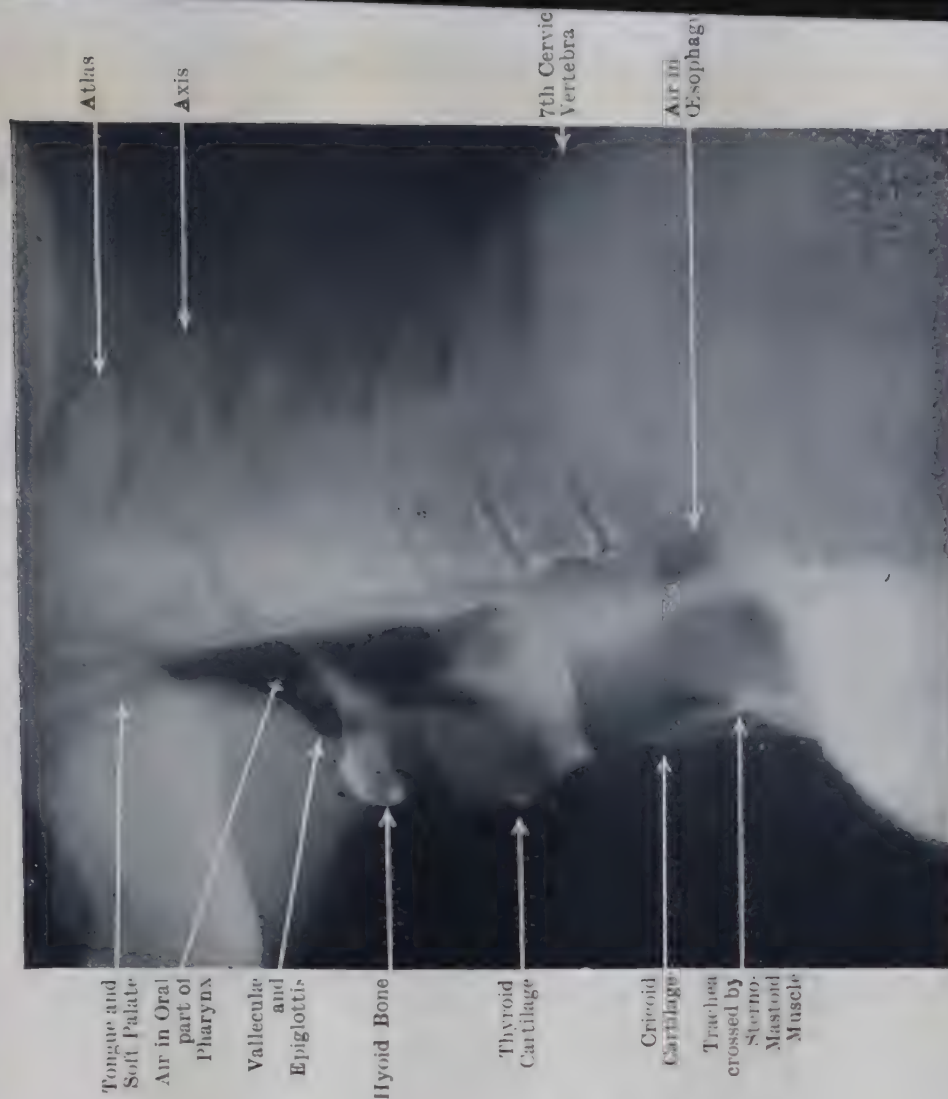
LATERAL RADIOGRAPH OF SHORTER NECK (MAN, AGED 74), SHOWING CAVITIES OF PHARYNX, LARYNX AND TRACHEA AND OSIFIED LARYNGEAL AND TRACHEAL CARTILAGES.
